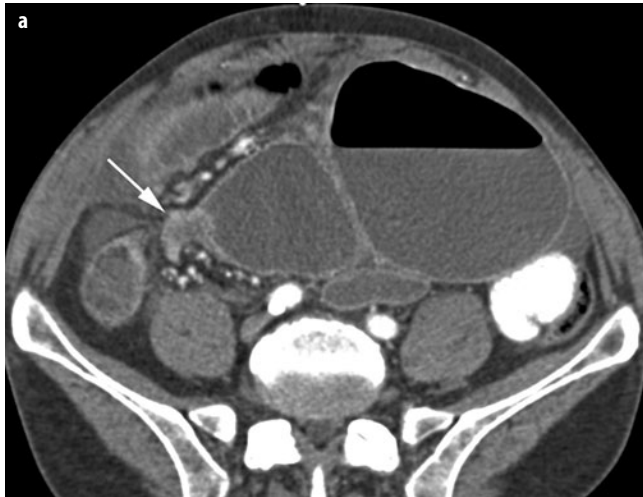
a, b. Cecal volvulus. a Transverse computed tomography (CT) image and b coronal CT reformation demonstrate a markedly dilated cecum (C) located in the midline and left lower abdomen and upper pelvis. The *arrows* point to the area of colonic twisting. Note the dilated small-bowel loops due to the proximal colonic obstruction
